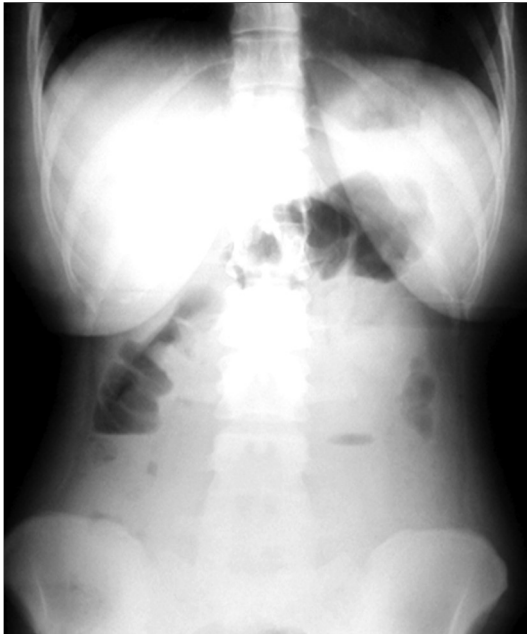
Plain abdominal radiograph on patient presentation showed only moderate distention of the ascending and transverse colon and solitary small intestinal air-fluid levels.
